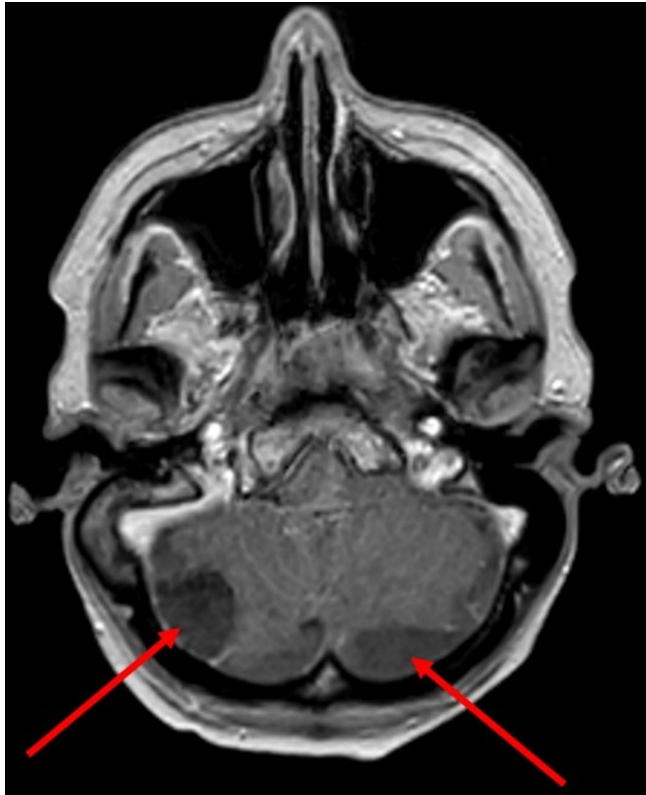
Cerebral MRI showing two cerebellar haematomas (arrows).
